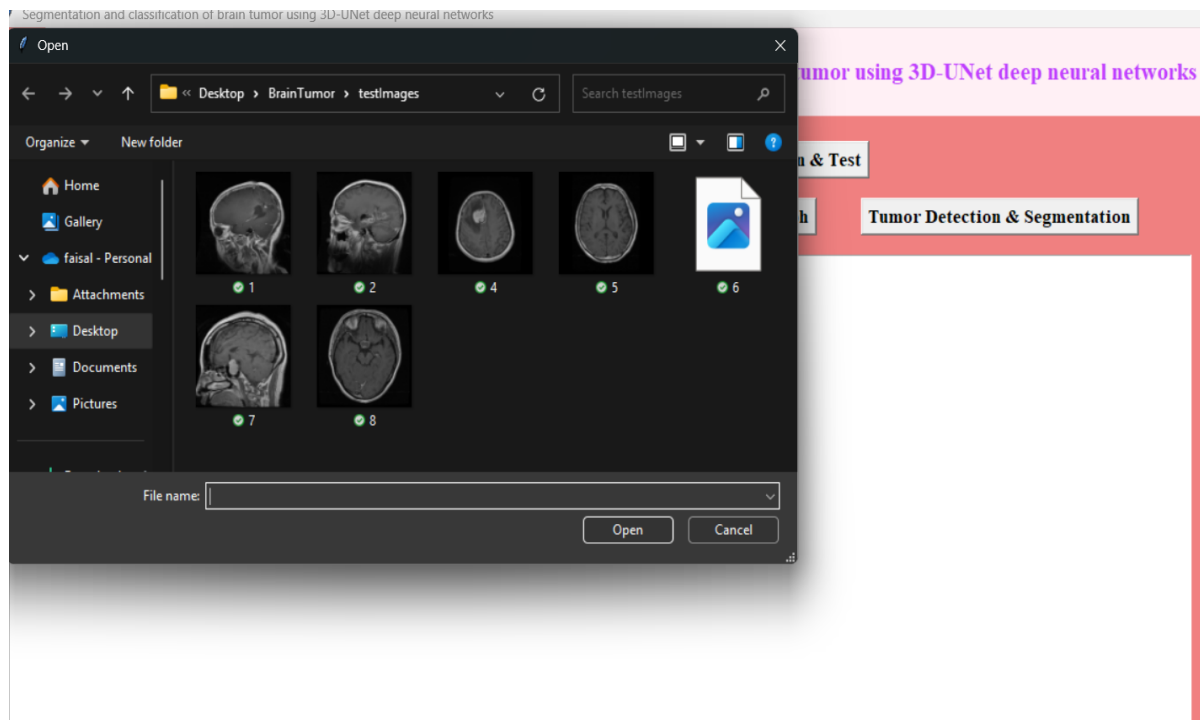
Uploading of MRI image for testing purpose
